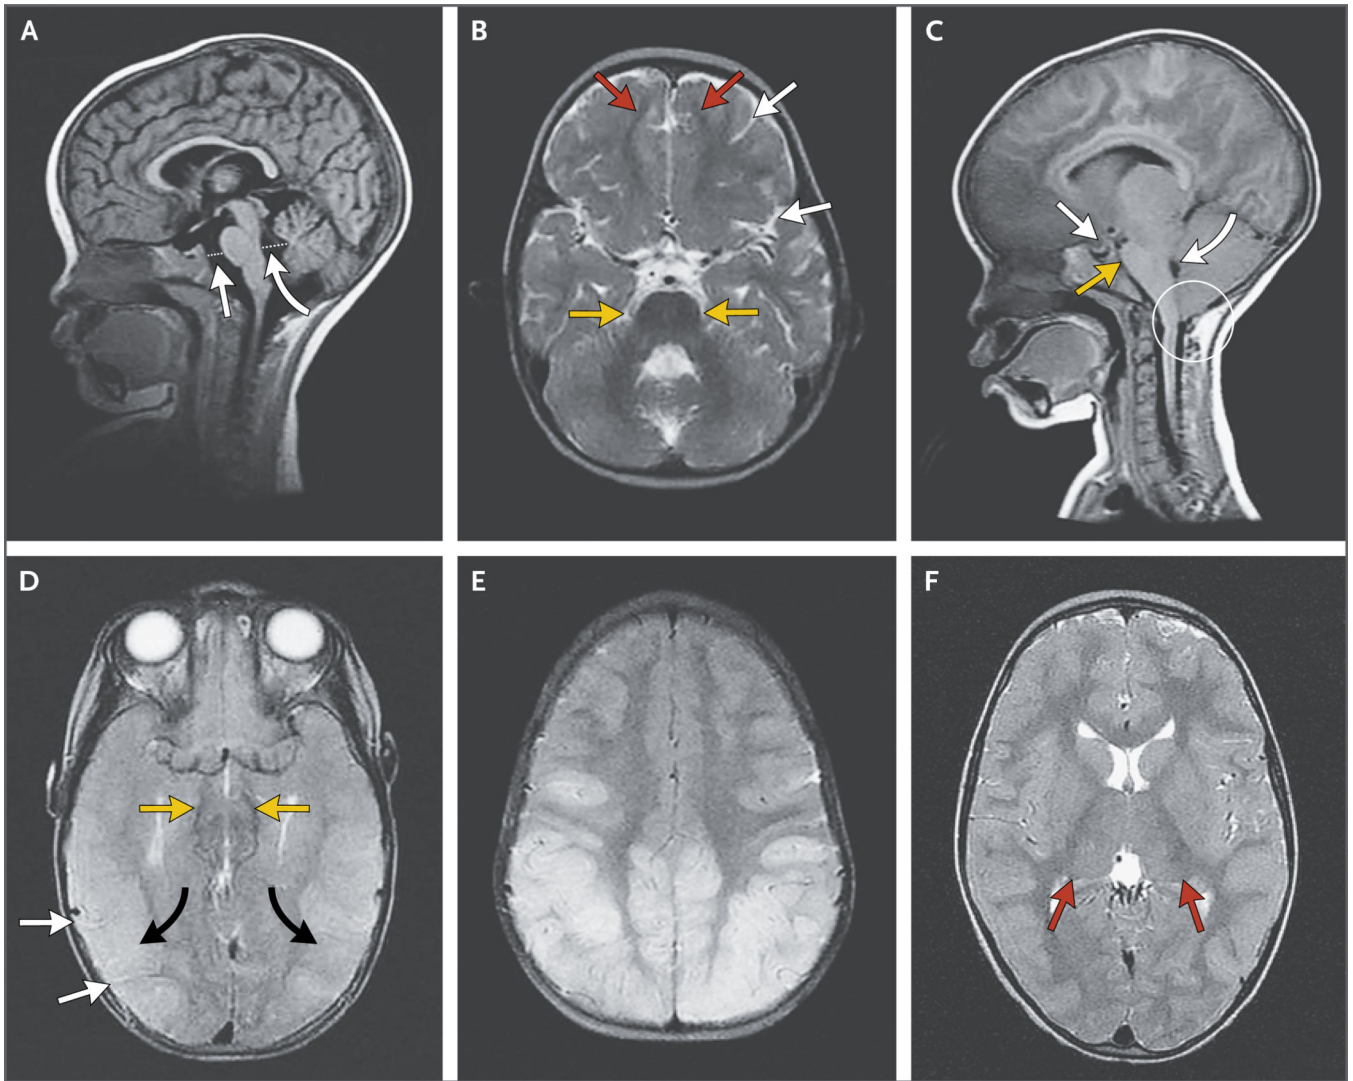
Brain Features on MRI in Children with Cerebral Malaria
